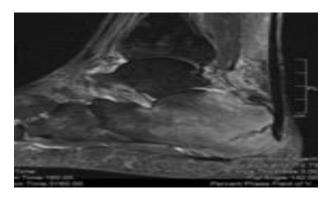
MRI scan that reveals posterior calcaneus fracture.
